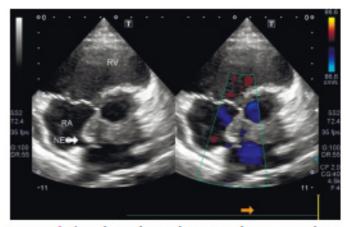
An echocardiographic image showing neoplasm in the anterior mediastinum.
